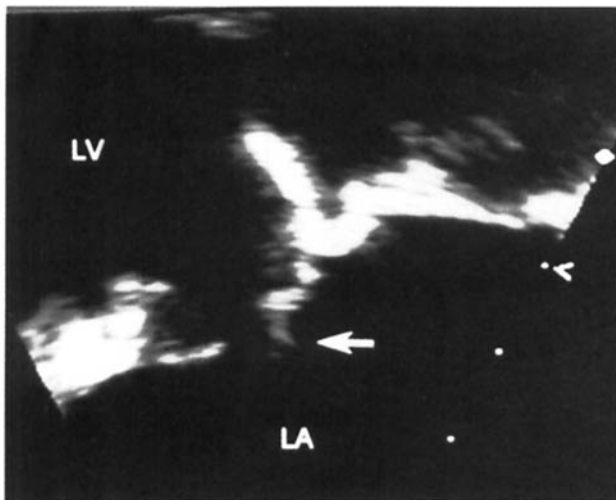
Enlarged multiplane transesophageal view shows flail motion of the posteromedial bioprosthetic valve leaflet. LA = left atrium, LV = left ventricle.
